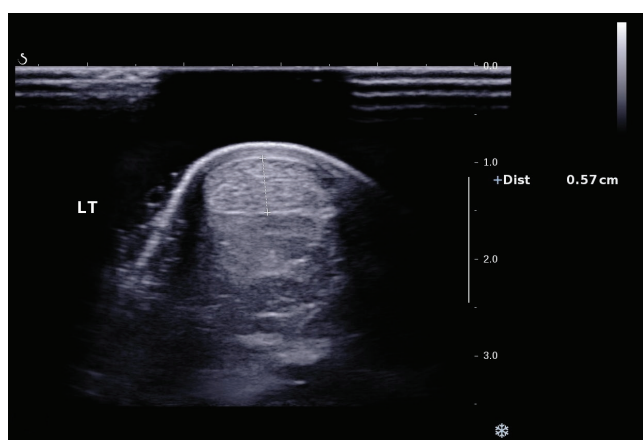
The power Doppler image of a tendon. The thickness of the left Achilles tendon was 0.57 cm
